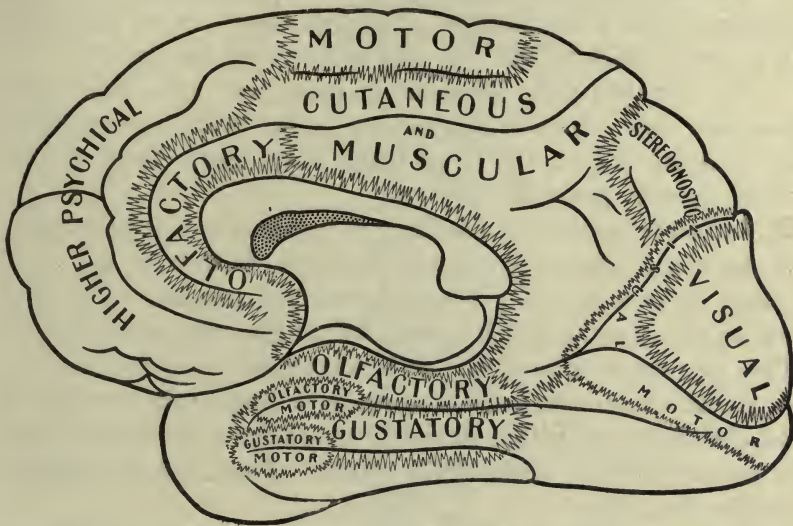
THE AREAS AND CENTERS OF THE MESIAL ASPECT OF THE HUMAN HEMICEREBRUM (C. K. Mills).
